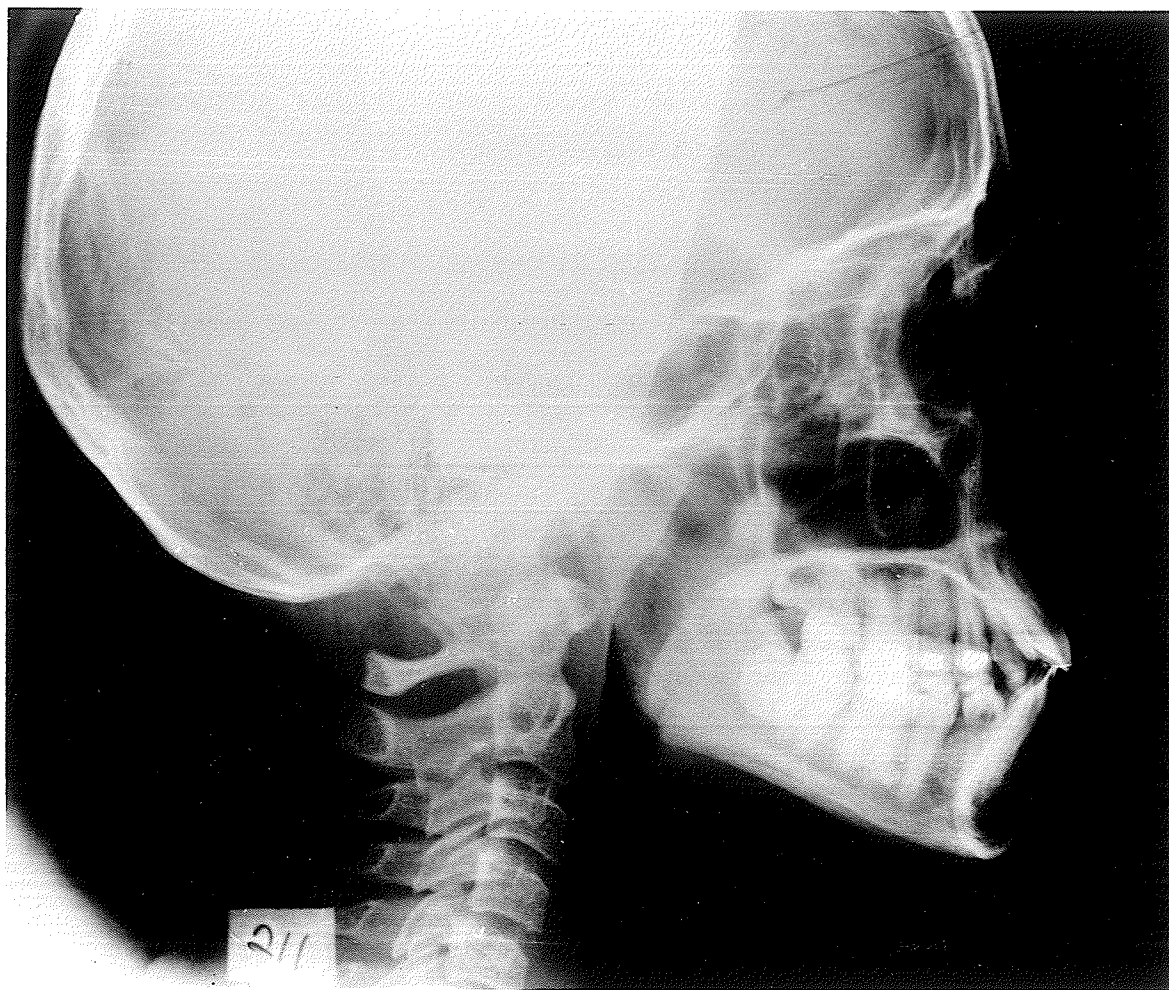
Lateral cephalometric radiograph of an Indian child aged 14 years 11 months.
